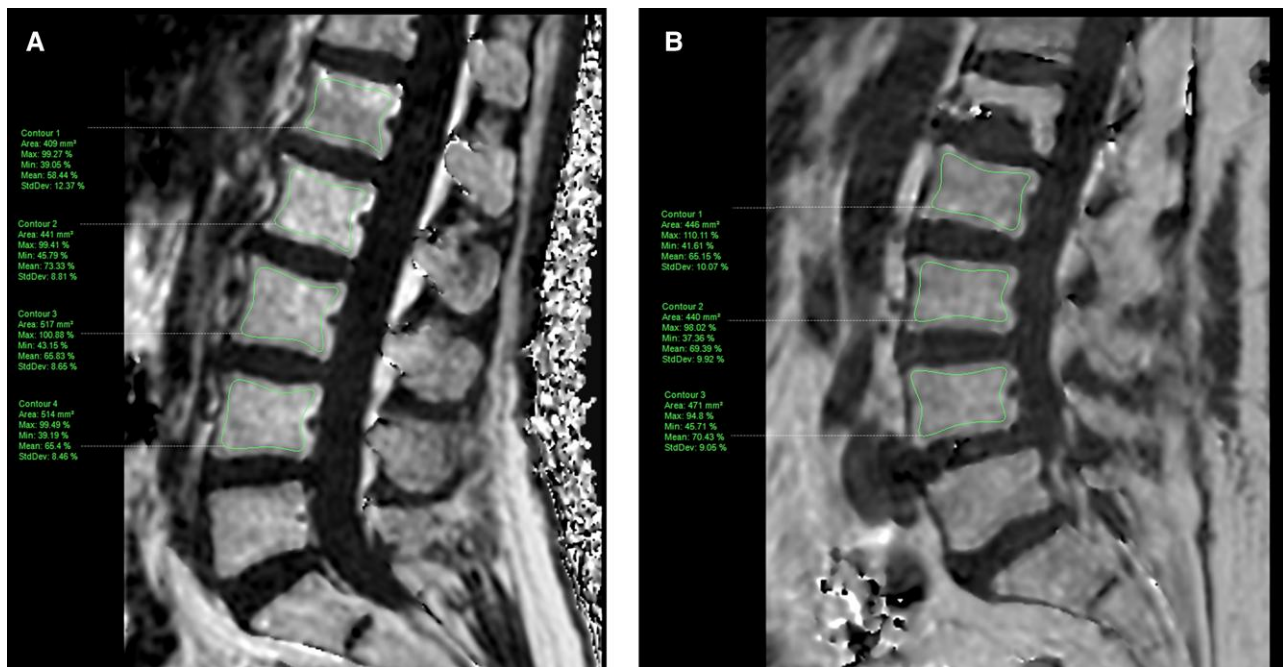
Imaging-based proton density fat fraction (PDFF) map of the lumbar spine. PDFF map of the lumbar spine computed from a T1-weighted, multiecho gradient echo sequence (mDixon-Quant) acquired in the sagittal plane, from an A, 61-year-old control and a B, 90-year-old patient (both postmenopausal women). Manually segmented regions of interest were placed in the L1 to L4 vertebral bodies, avoiding the immediate subchondral bone, the cortical bone and the basivertebral vein. L1 was excluded for patient B, as it was fractured.
